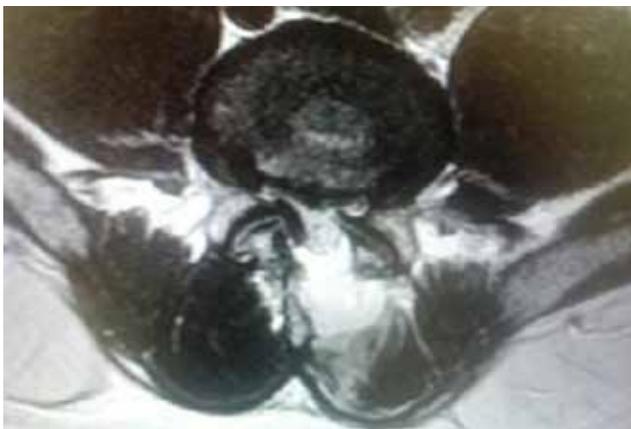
Post-operative axial magnetic resonance imaging showing complete decompression of lumbar spinal stenosis at the L4-5 level.
